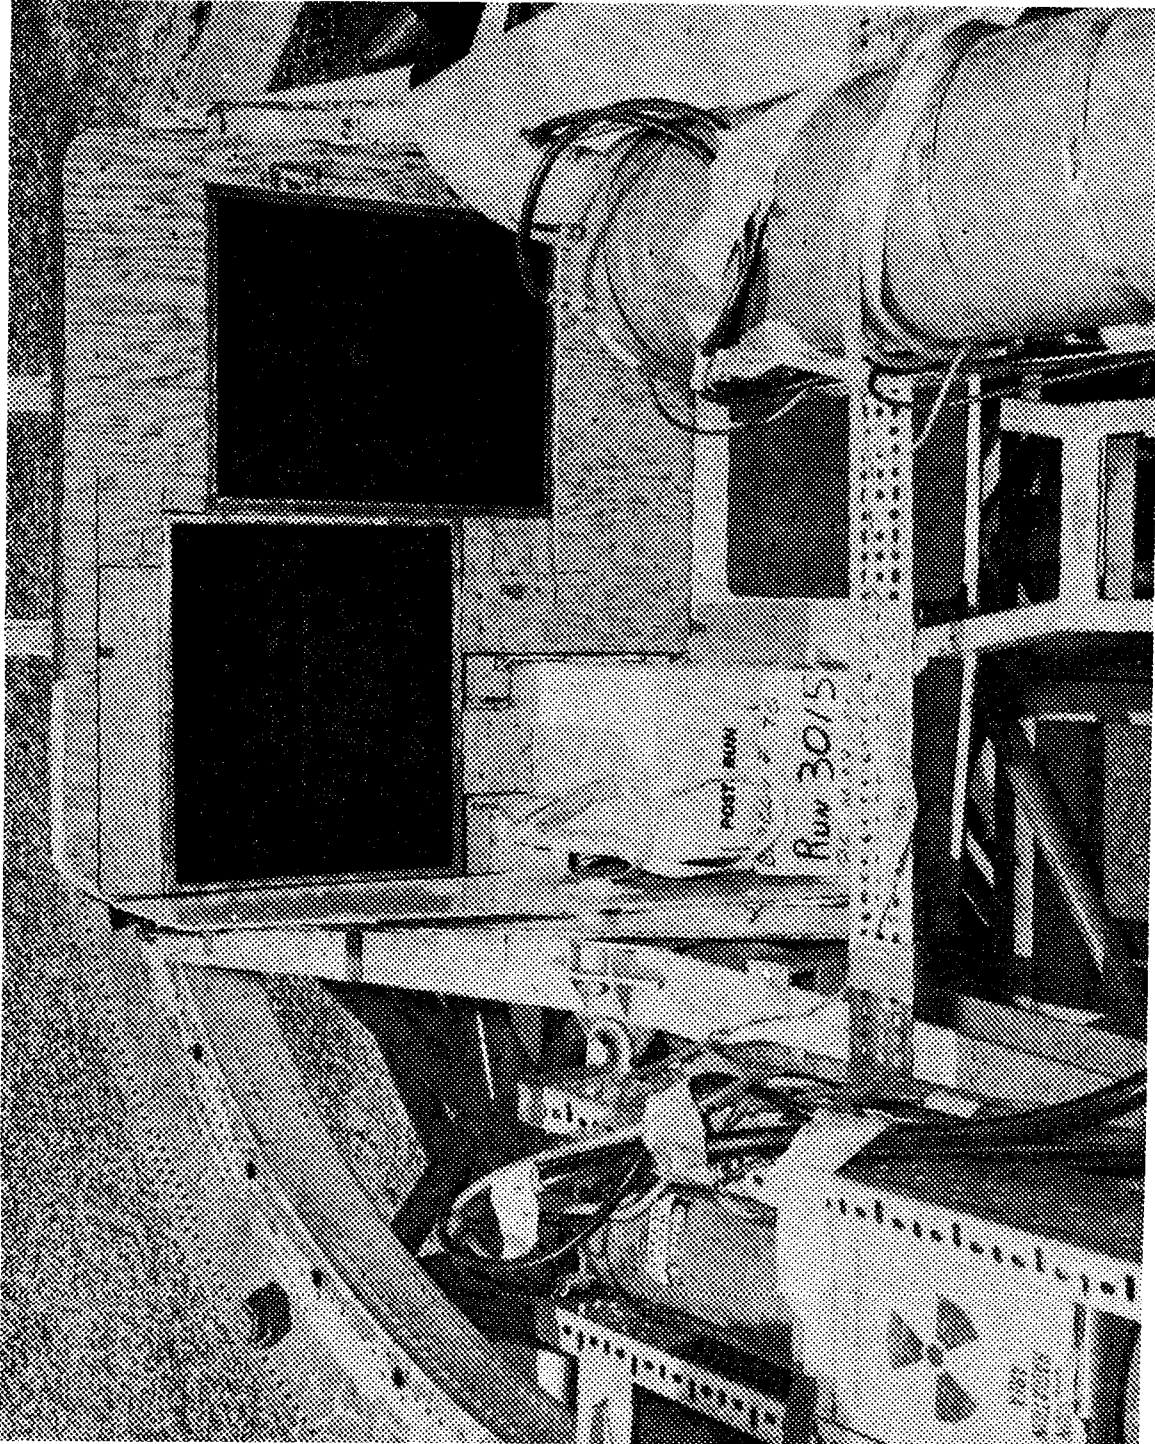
Sled seat post-impact with photometric backing removed to show location of dual X-ray cassettes mounting. One roentgenogram was obtained at impact and a second could be set for any time during the sequence of lateral movement.
